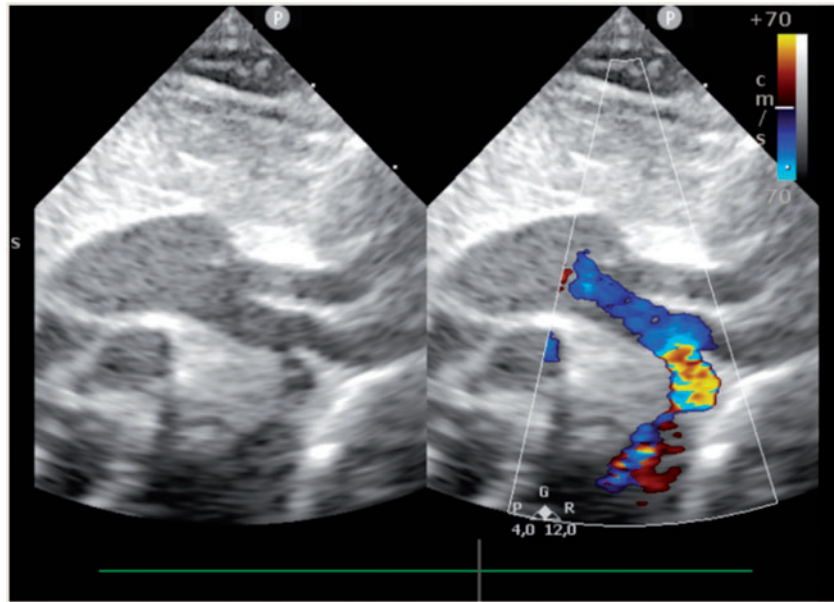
Transthoracic echocardiography demonstrating mild hypoplasia of the aortic arch associated with localized isthmic coarctation. The aortic tract between the aortic arch and the coarctation was oddly configured and could not be clearly visualized.
